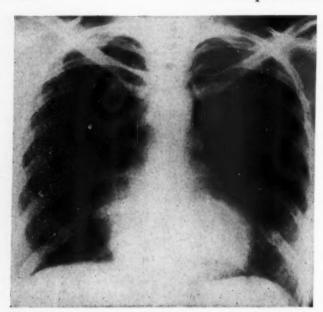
Chest roentgenogram of patient F. C. with isolated tricuspid stenosis. Note enlarged right atrium with normal right ventricle, pulmonary arteries, left atrium and ventricle (confirmed by angiocardiogram).
